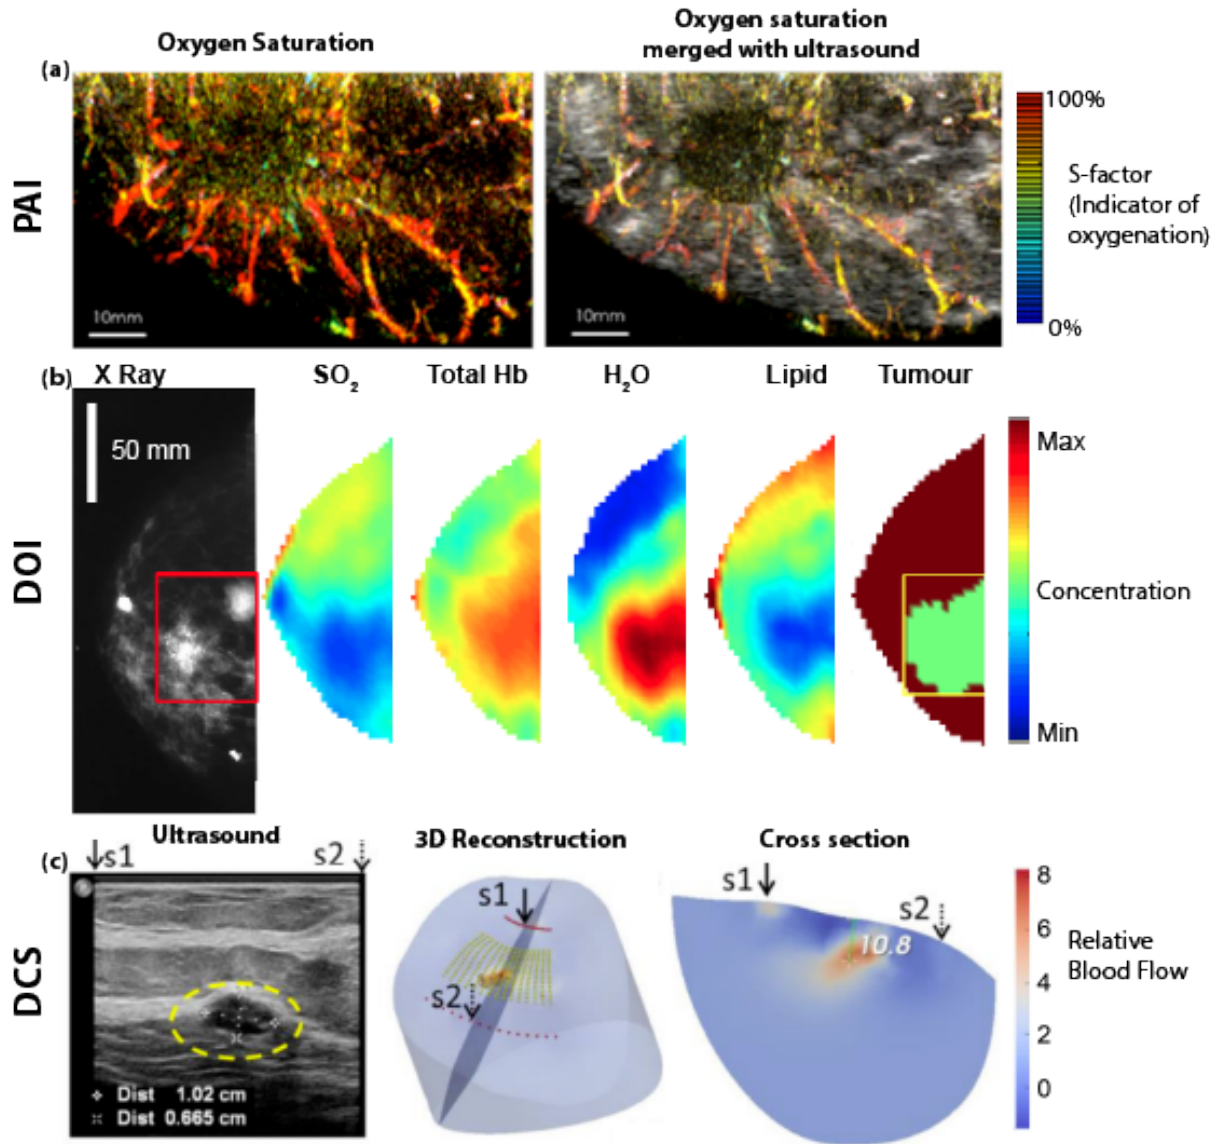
Tomographic imaging of the human breast for cancer detection (a) PAI of sO_2 in a breast with infiltrating ductal carcinoma (IDC); S-factor was defined to account for system accuracy and fluence compensation.¹⁶⁵ (b) DOI of breast IDC (indicated by the red box) resolves sO_2 , THb, H_2O , Lipid, concentrations of which serve to highlight the tumor.¹⁶⁶ (c) Diffuse correlation spectroscopy (DCS) of blood flow relative to an ultrasound image of low-grade carcinoma where the tumor is circled in yellow. These images are referenced to positions s1 and s2 to compare the ultrasound, 3D reconstruction, and cross section.¹⁶⁷
